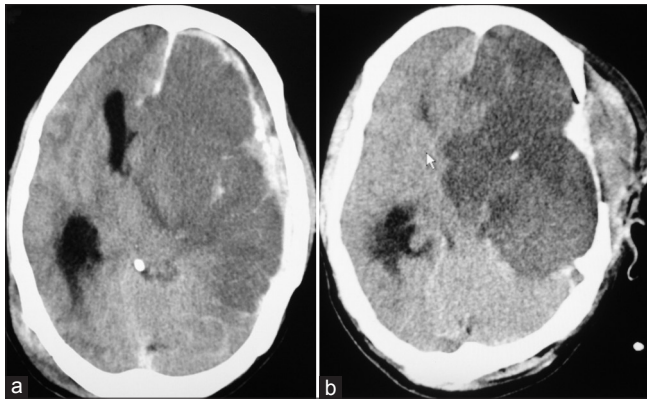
(a) Plain CT head of first patient showing left ICA territory infarct with mass effect and associated acute subdural hematoma. (b) Repeat CT after 24 h showing evidence of left fronto-temporo-parietal craniotomy and well-developed infarct in the same territory
